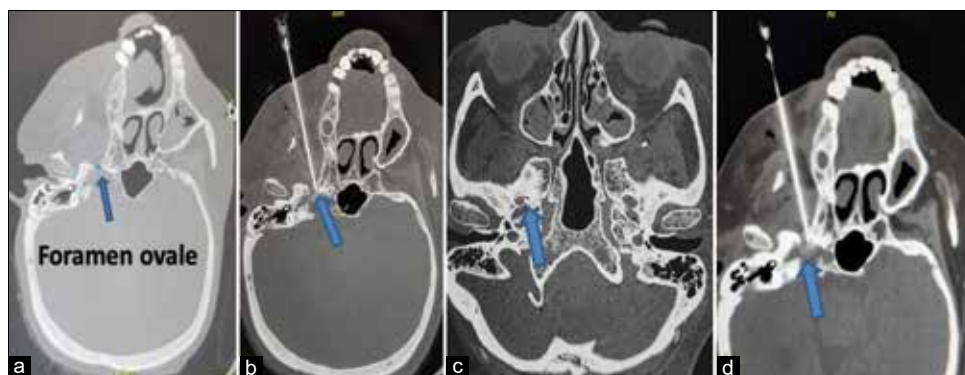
Computed tomography brain sections with blue arrows showing (a) foramen ovale, intra-procedure: needle tip (b and c) in the medical aspect of foramen ovale with drug percolation (d)
